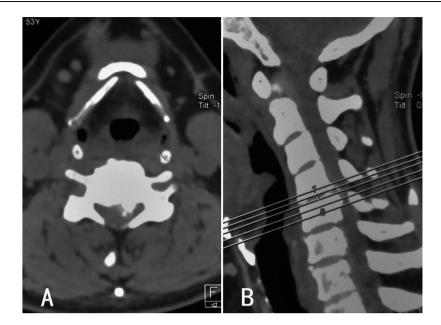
CT. Calcification of left-sided herniated C4-C5 disc (A) and posterior vertebral osteophyte of C5 (B). To deal with the osteophyte, subtotal vertebrectomy and titanium mesh cages reconstruction were selected for decompression.
